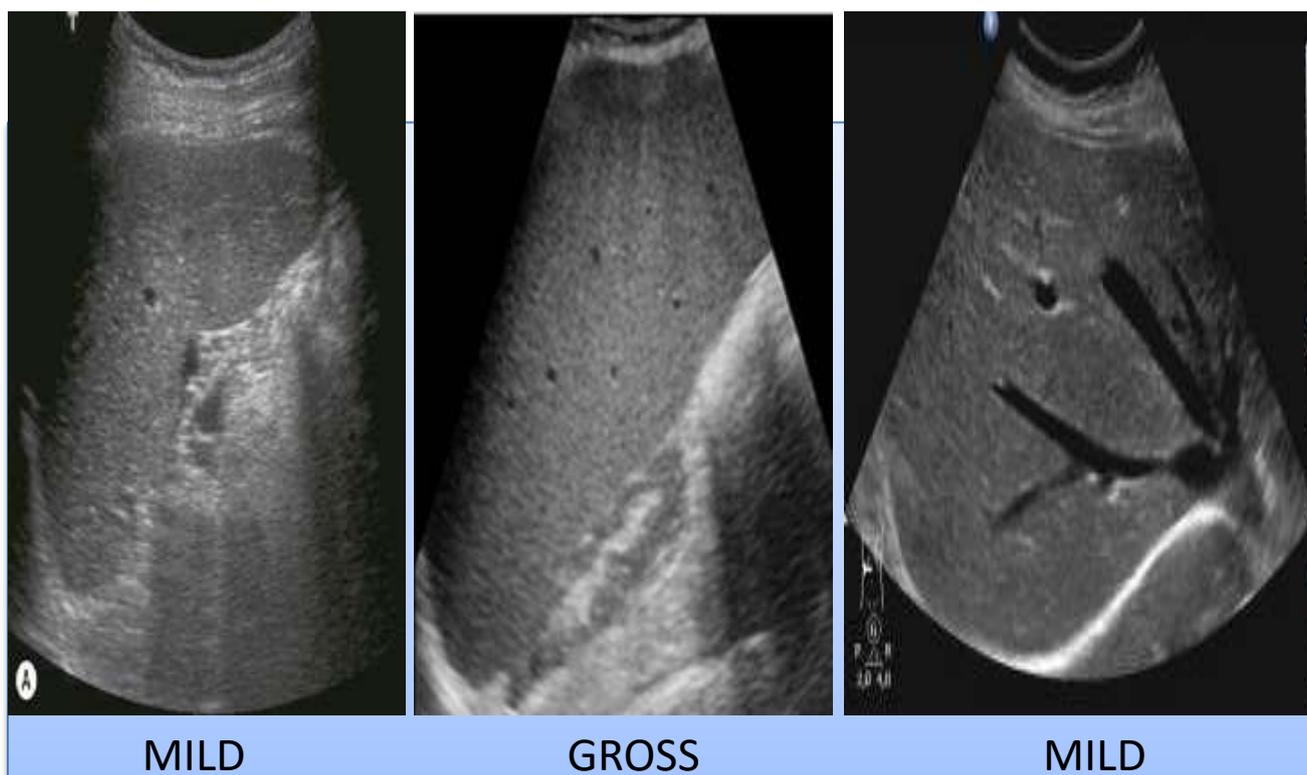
Splenic and hepatic enlargement noted on ultrasound
